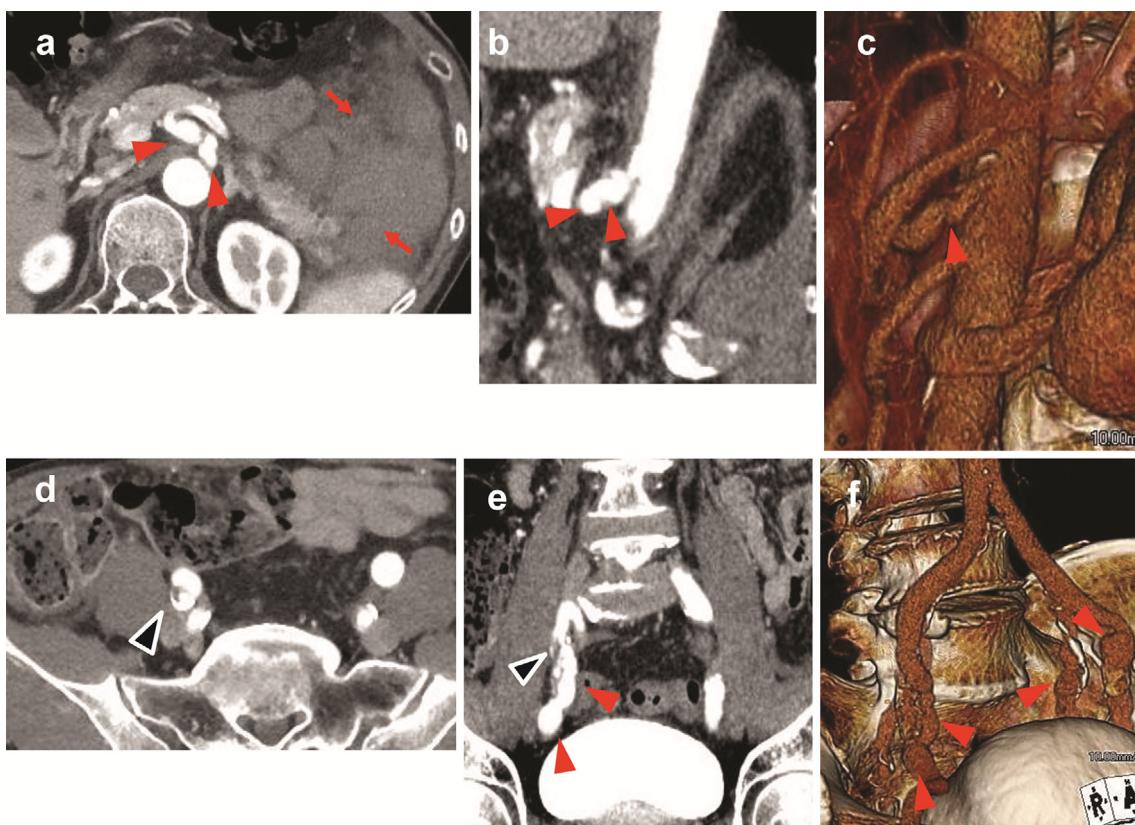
Imaging studies of SAM in Case 2. (a, b, c) Computed tomography (CT) and three-dimensional reconstruction showed bleeding in the abdominal cavity (red arrows) and dissecting aneurysm (red arrowheads) in the celiac artery to splenic artery. (d, e, f) The bilateral external iliac arteries showed multiple aneurysmal changes (red arrowheads) and partial dissection (black arrowheads in d and e). SAM: segmental arterial mediolysis
